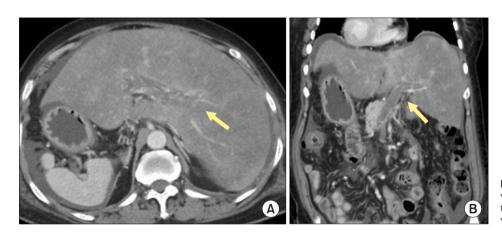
Computed tomography showing situs inversus totalis, diffuse hepatomegaly, liver congestion, and thrombus in the branches of the portal vein (arrow) (A) and its main trunk (arrow) (B).
